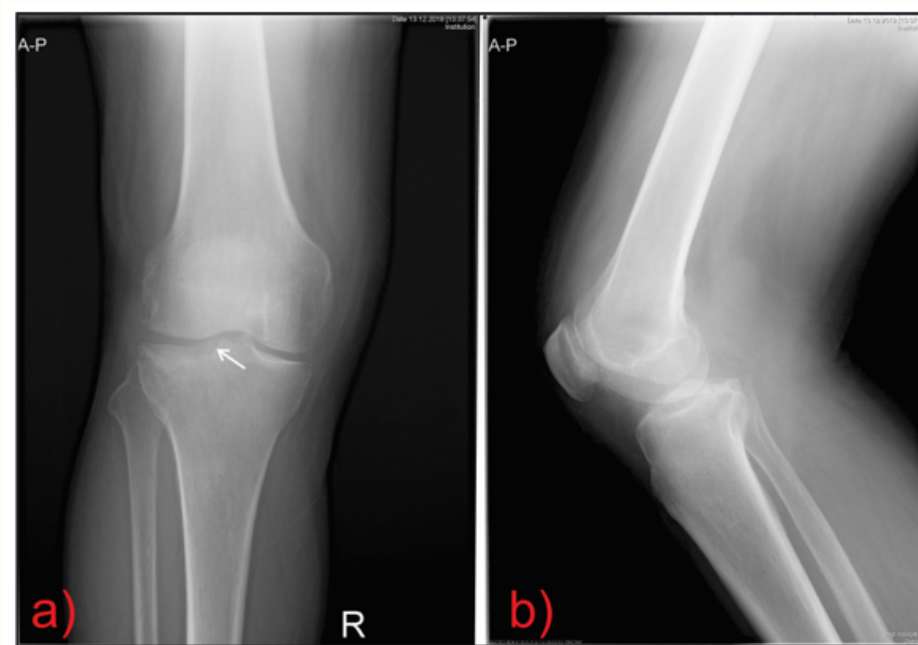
(a) Anteroposterior view of the right proximal tibia showing the initial injury (look at the arrow), (b) lateral view of the right proximal tibia (imaged on 13.12.2019). Note the degree of articular depression better appreciated on MRI scan.
